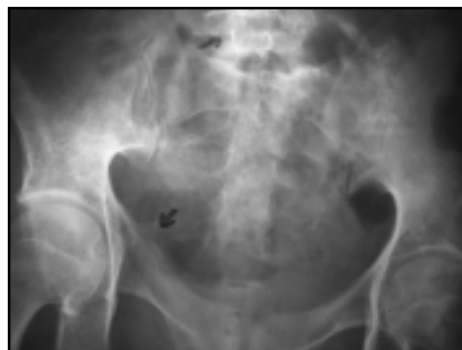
X-ray pelvis showing destruction of sacrum, L4 & L5 vertebra
